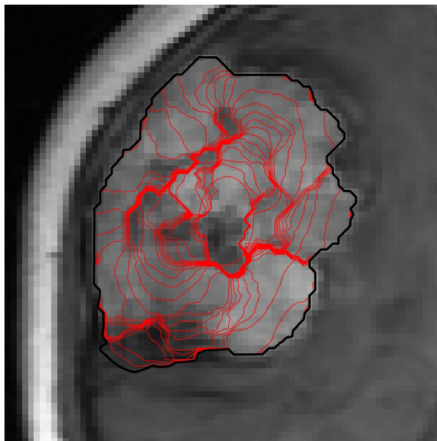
A magnified inside-out model evolution of an initial contour inside a brain tumor (Meningioma) in raw T1-weighted contrast enhanced image.
